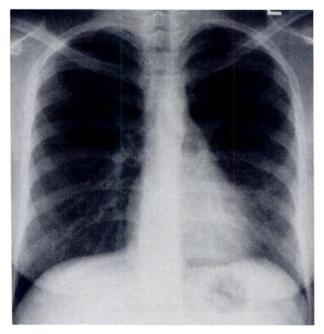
Roentgenogram of the chest showing near total resolution of the lingular infiltrate.
